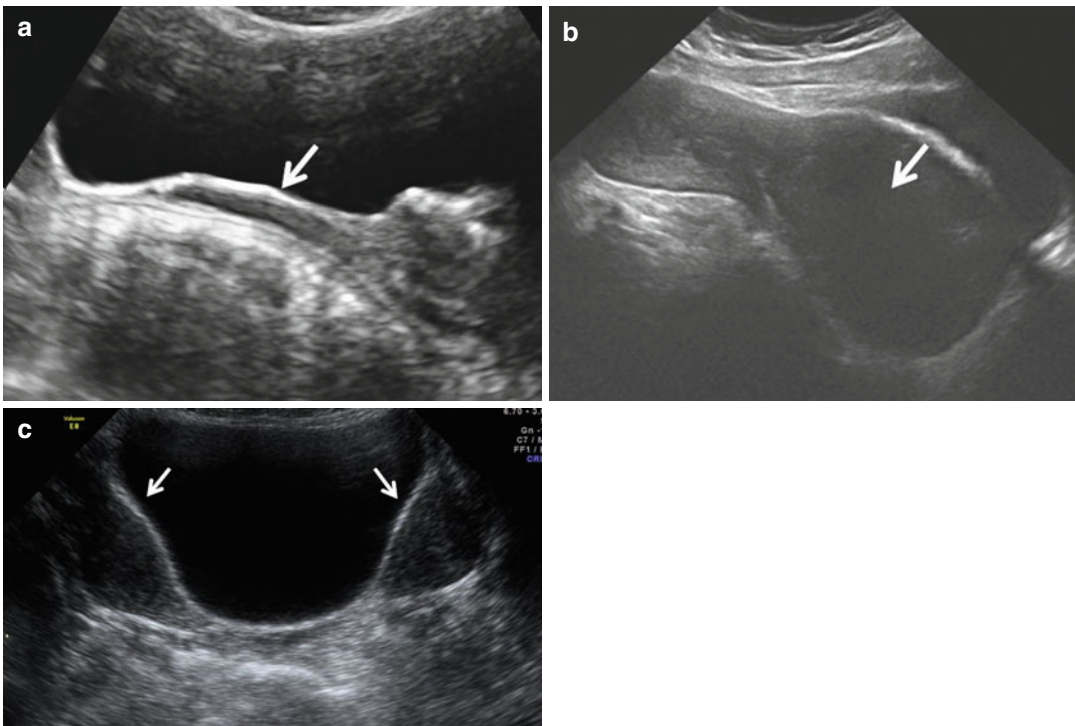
Abdominal 2D ultrasound: (a) uterine agenesis: ESHRE/ESGE U5b C4 aplasia: vagina (*white arrow*), absent cervix and uterine body. (b) Transverse vaginal septum/imperforate hymen: ESHRE/ESGE U0 C0 V3:
